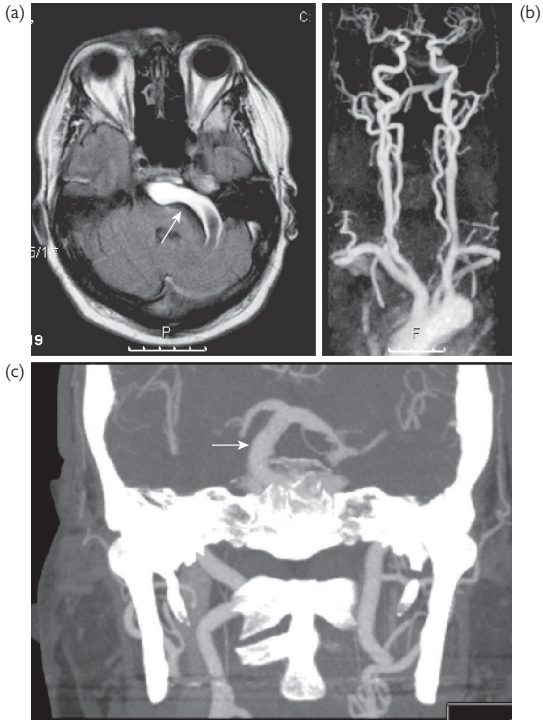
Pictures of dolichoectatic basilar artery. (a) On the MRI there is a dilated and tortuous basilar artery. This is confirmed on the contrast-enhanced MRA (b) and on the CTA (c). The abnormality is arrowed.
